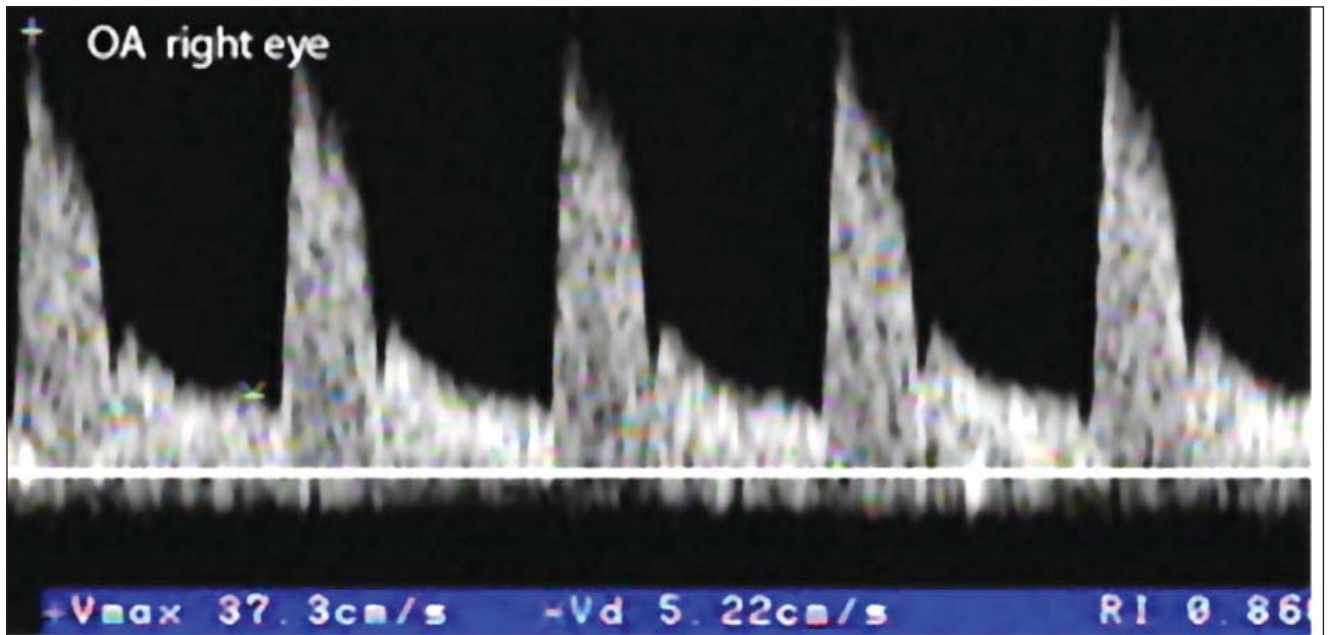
b Patient TL-Spectral Doppler analysis of ophthalmic arteries (OA).
